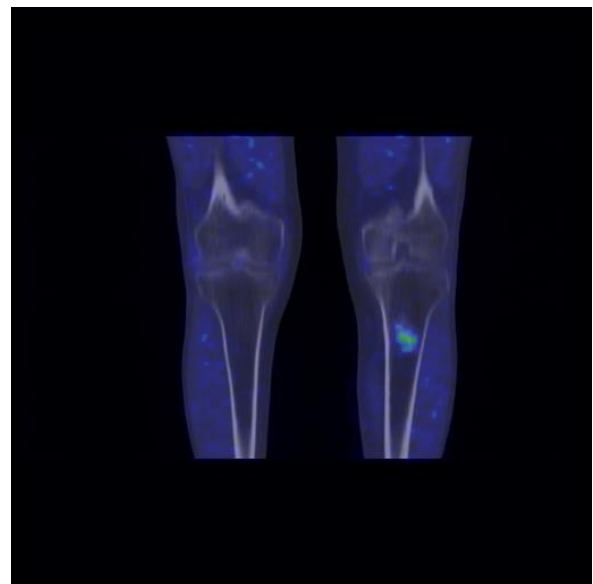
Coronal view of and fused ^{11}C -choline PET/CT images (C) of the inferior limb at knee height. There is a region of increased uptake of ^{11}C -choline in the area of bone thickening evident in the CT scan.
